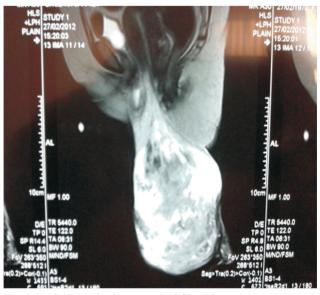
MRI showed a large cervical fibroid measuring 22 x 12 x 14cms arising from anterior lip of the cervix traversing through the introitus & herniating to the exterior. The fundus & the body of the uterus appeared normal
